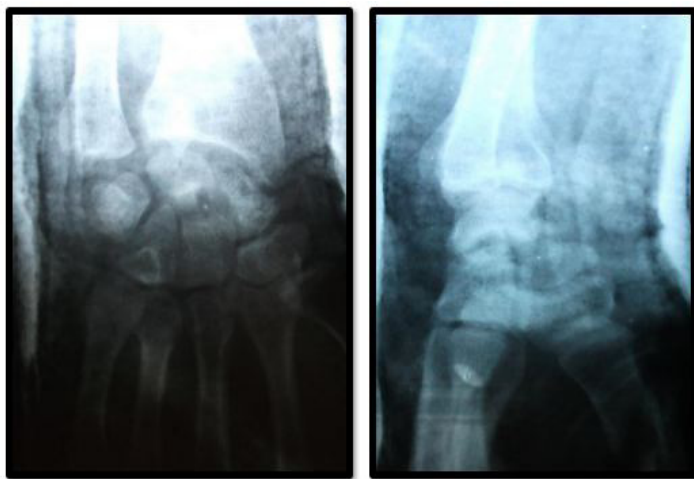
Left wrist X-Ray three weeks after the initial trauma showing the capitate head fracture.
